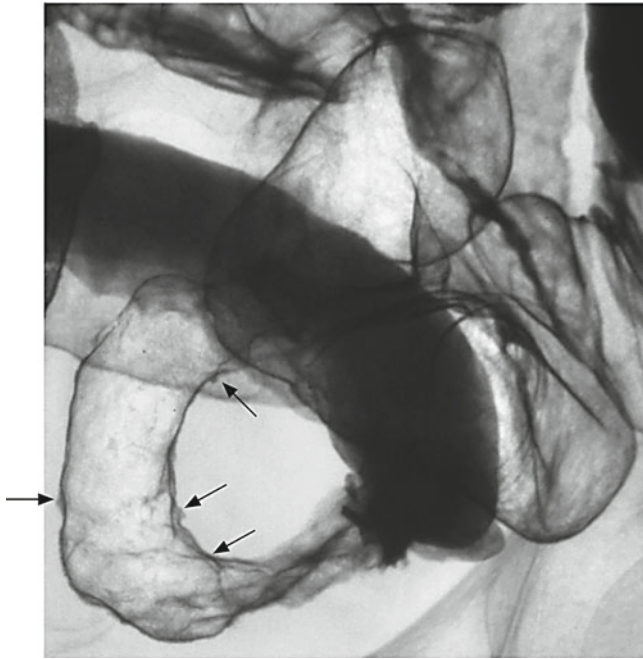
Case 19: Radiography undertaken during the same period as endoscopy revealed numerous small barium flecks (*arrows*) in the ileum
